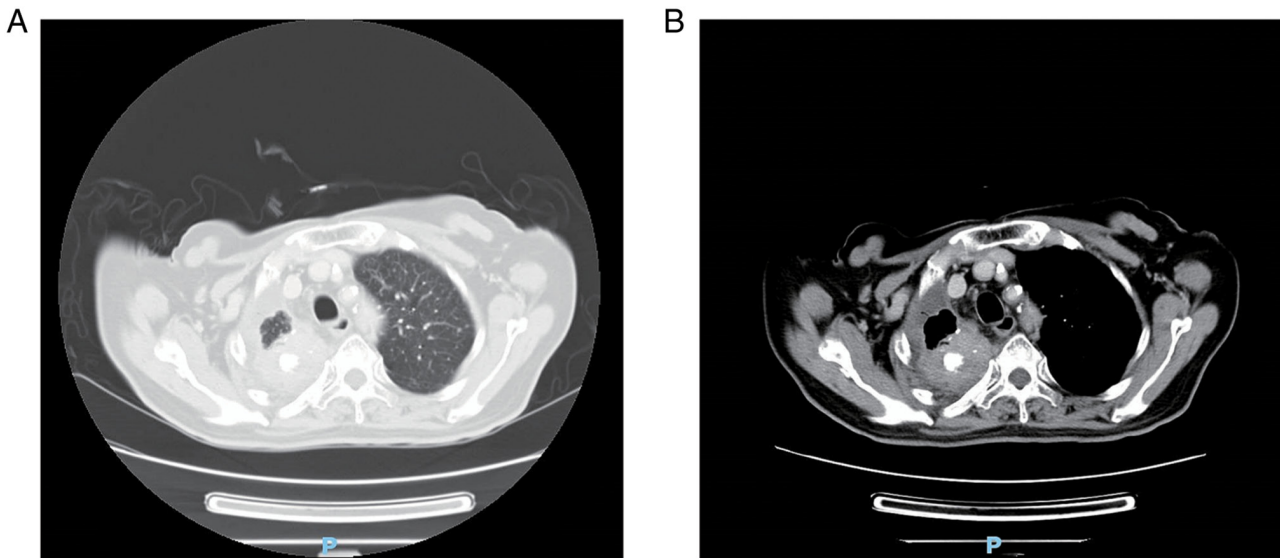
Chest computed tomography of case 2 in July 2021. (A) A pulmonary irregular tumor mass with calcification in the right upper lobe with a diameter of 5.0 cm (lung window), (B) A pulmonary irregular tumor mass with calcification in the right upper lobe with a diameter of 5.0 cm (mediastinal window).
